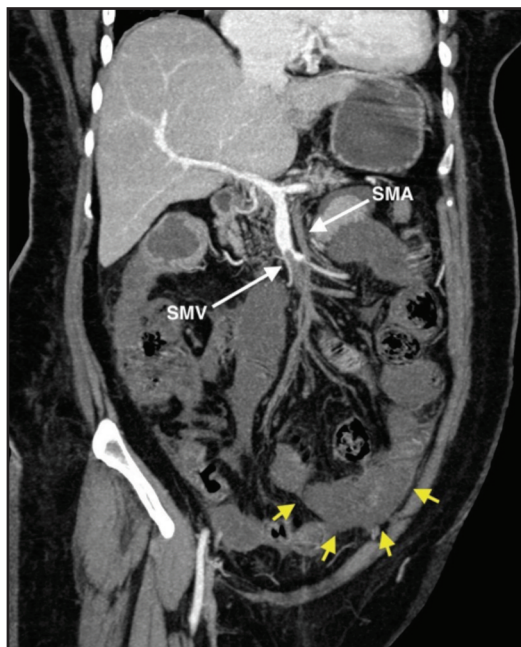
Porto-venous phase computed tomographic angiography (Angio-CT) of abdomen and pelvis. Labelled image with long arrows shows filling defect within the SMA and SMV suggestive of emboli with non-enhancing bowel loop (short arrow).
